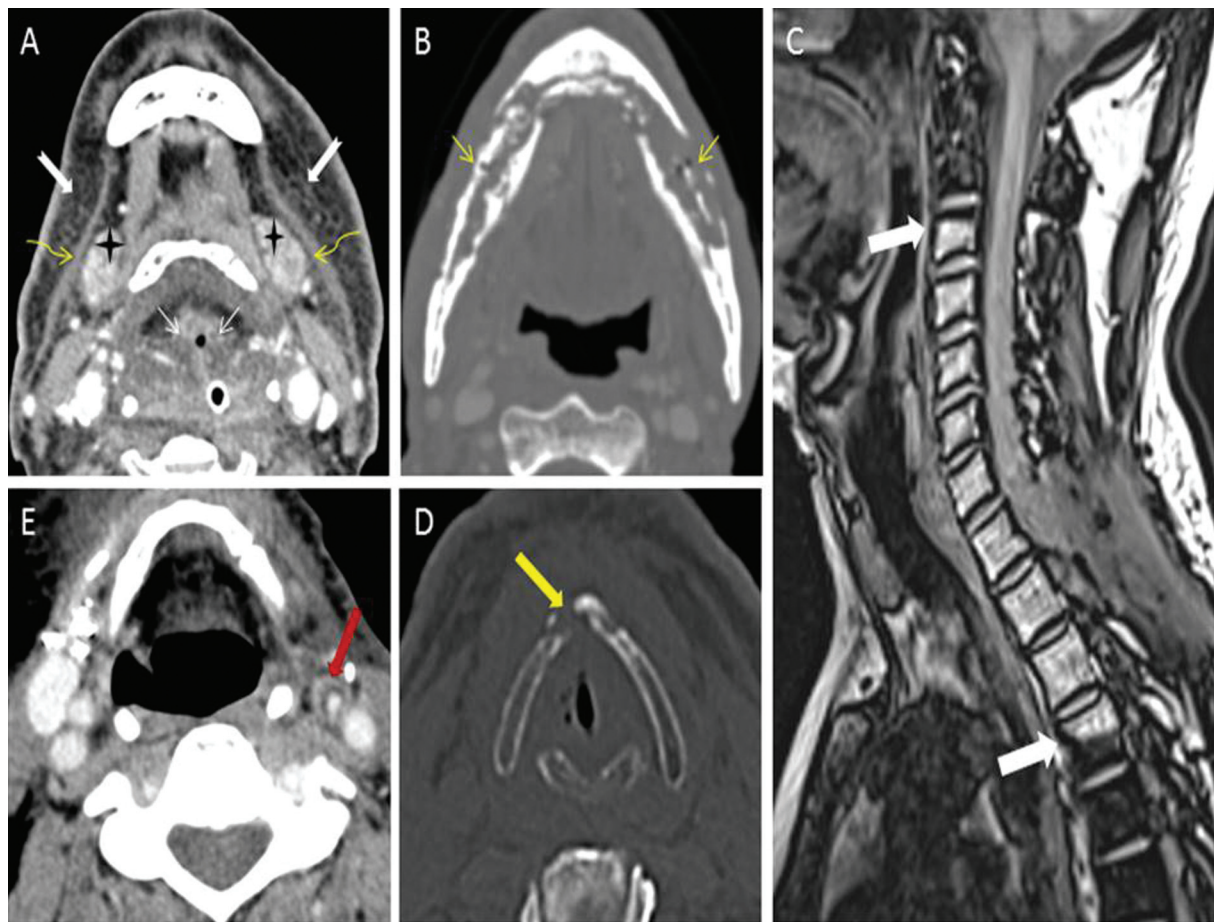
(A) Expected radiotherapy (RT)-related soft tissue changes. Axial contrast-enhanced computed tomography (CT) image in soft tissue window shows diffuse bilateral subcutaneous fat reticulations (notched white arrows), thickened bilateral platysma muscles (curved yellow arrows), increased enhancement of bilateral submandibular glands (black stars), and edema of hypopharyngeal structure (thin straight white arrows). (B) Radiation-induced osteonecrosis. Axial contrast-enhanced CT image in bone window shows bizarre lysis, fragmentation, and sclerosis of the mandible (thin straight yellow arrows). Absence of expansile soft tissue at site of bone destruction rules out the possibility of recurrence. (C) Radiation-induced fatty marrow conversion. Sagittal Dixon T1-weighted fat magnetic resonance (MR) image shows conversion to fatty marrow from C3-D4 vertebrae with sharp margins at mid-C2 and mid-D4 levels (thick white arrows) corresponding with the radiation portal. (D) Radiation-induced chondronecrosis. Axial noncontrast-enhanced CT image in bone window kernel shows lysis of thyroid cartilage (thick yellow arrow) with air foci in the vicinity of the right vocal cord. (E) Radiation-induced atherosclerosis. Axial contrast-enhanced CT image in soft tissue window shows fatty atherosclerotic mural changes in the left external carotid artery (thick red arrow) causing luminal stenosis.
